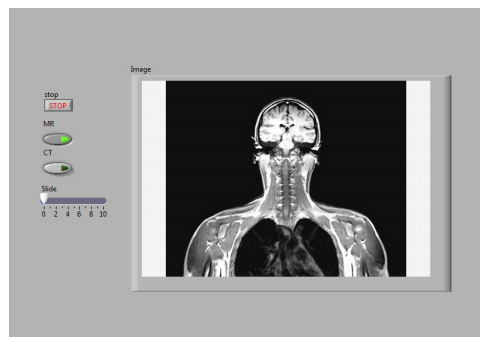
The finished program showing a MR image.
